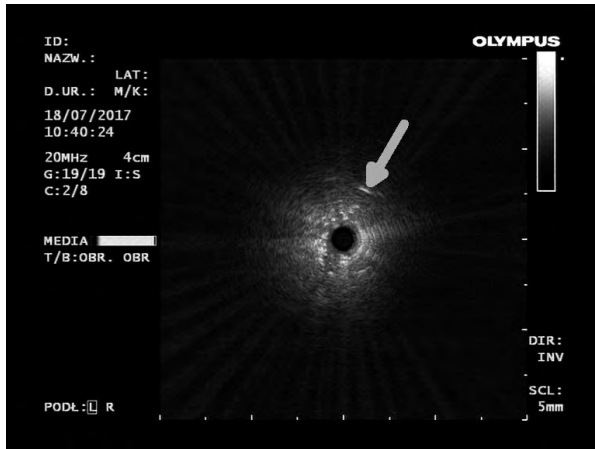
Ultrasound imaging of the visceral pleura (white arrow) obtained with radial endobronchial ultrasound mini-probe — rEBUS. With the consent of the Archives of Endoscopy Unit of Pulmonary Hospital, Zakopane
